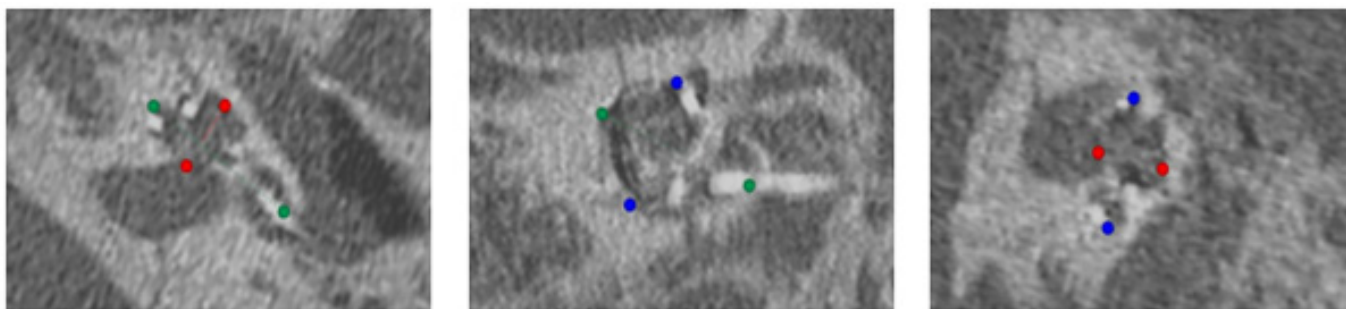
OTOPLAN-based measurements of the postoperative CT scans: (A) A value (green dot on red line), (B) cochlear width (B value; blue dot on red line), and (C) cochlear height (H value; red dot on green line). Axial, coronal, and sagittal CT views are shown. The red arrows and hand-drawn red line indicate the fracture gap in the CT images.
